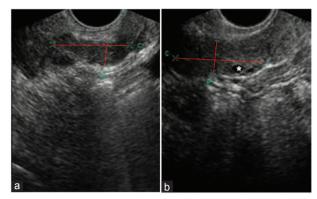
Ultrasound images of SVs before ejaculation. (a) SV of control case. (b) SV of patient with PE. Areas of endocapsulation (*). The red line indicates the LD and the APD. APD: anterior-posterior diameter; LD: longitudinal diameter; PE: premature ejaculation; SV: seminal vesicle.
